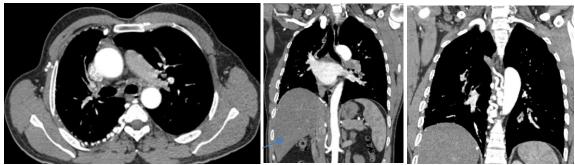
Contrast-enhanced chest CT in axial and coronal planes demonstrates mediastinal and subpleural collateral circulation arising from the right internal mammary artery, the bronchointercostal trunk, and a subdiaphragmatic collateral originating near the origin of the right renal artery (arrow)
